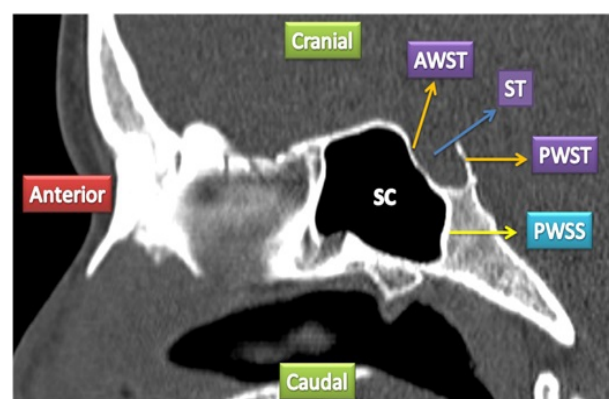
A sagittal CT slide of sphenoid sinus of a 23 year old female showing sellar pneumatization. AWST = Anterior Wall of Sellar Turcica, ST = Sellar Turcica, PWST = Posterior Wall of Sellar Turcica, PWSS = Posterior Wall of Sphenoid Sinus, SC = Sinus Cavity
